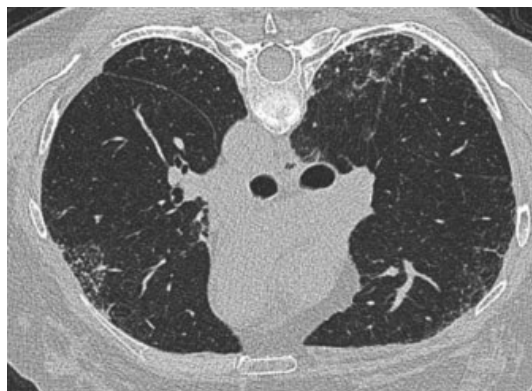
Representative chest CT findings from an individual with HPS-1. HPS, Hermansky-Pudlak syndrome.
